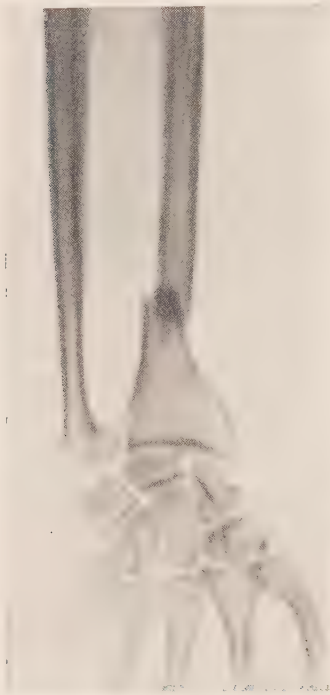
Fracture of the lower third of the radius. (Roentgenogram by Dr. G. C. Bird.)
